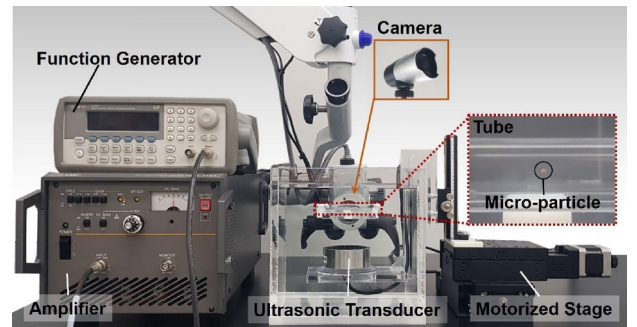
Experimental setup for ultrasonic actuation.
